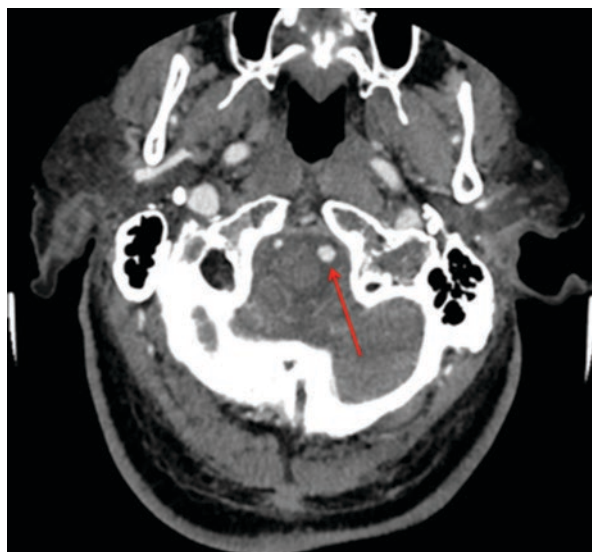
Vertebral artery dissection (*arrow*). CTA image of a left vertebral artery dissection with flap resulting in acute neck pain and vertigo
